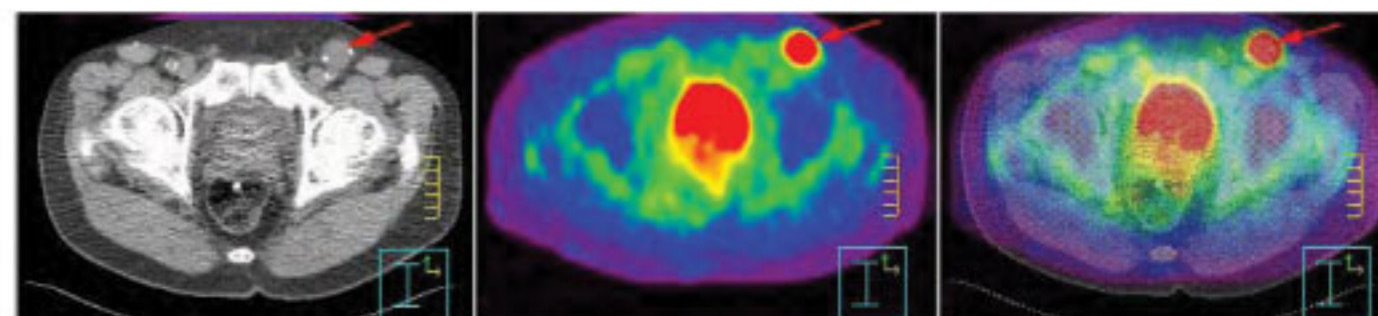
PET (middle) and PET-CT (right) axial section through the inguinal region show a focally bright-red uptake (red arrows) corresponding to the lymph node shown on axial CT (left).
